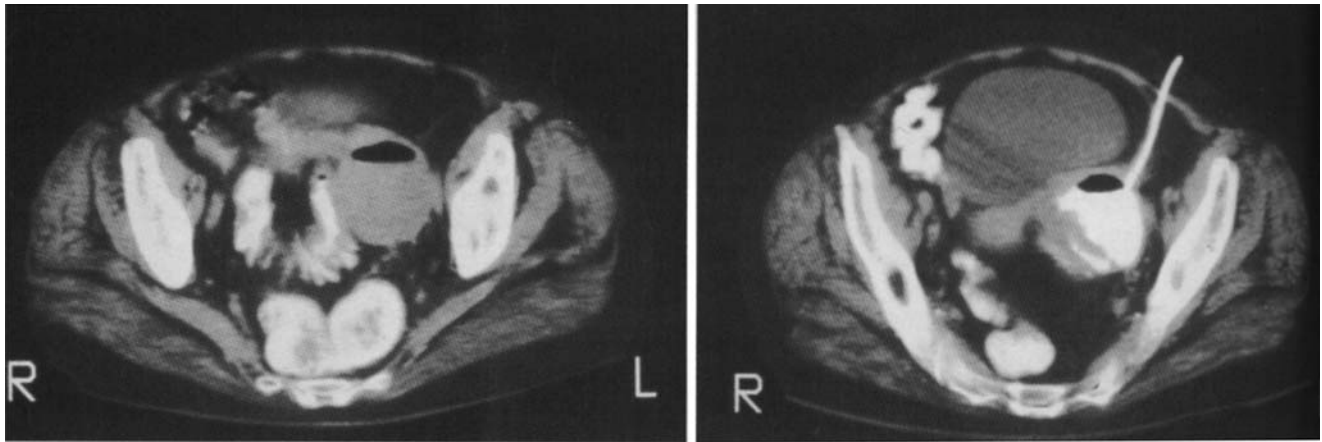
Computed tomography scan of patient pre- and postinterventional radiologic drainage of a pericolic abscess. (From Welton et al.,²¹ with permission of Springer Science + Business Media.)
